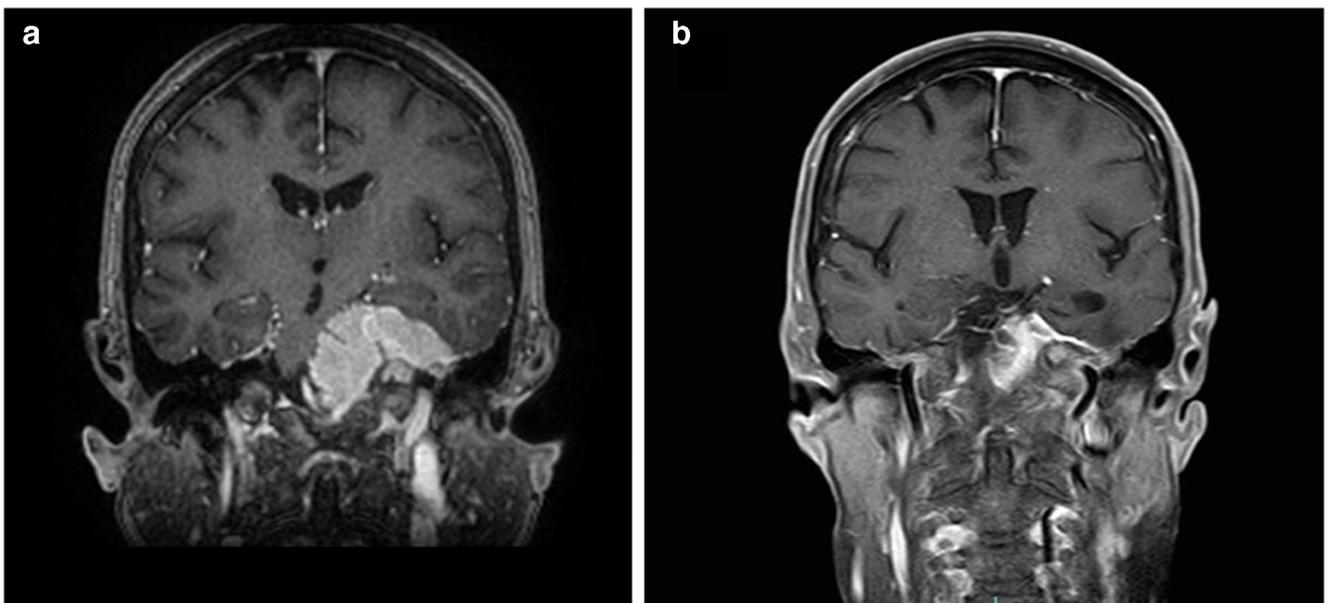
Coronal contrast-enhanced T1-weighted MR images demonstrating preoperative tumor burden (left) and postoperative intracavernous residual (right) after *extradural minipterional pretemporal approach* for subtotal resection and cavernous sinus decompression
